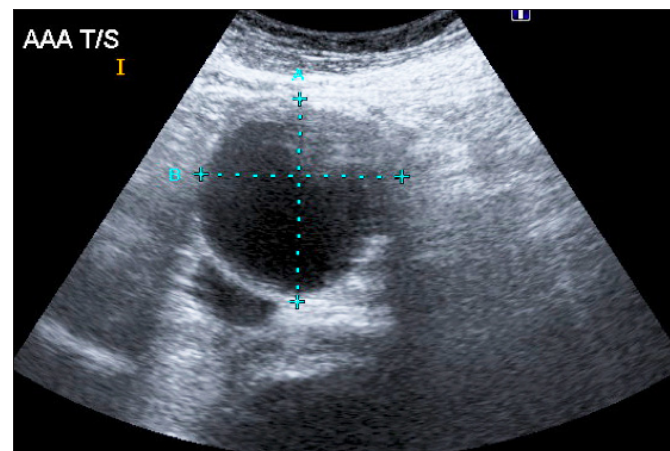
AAA displayed by ultrasound scan.
